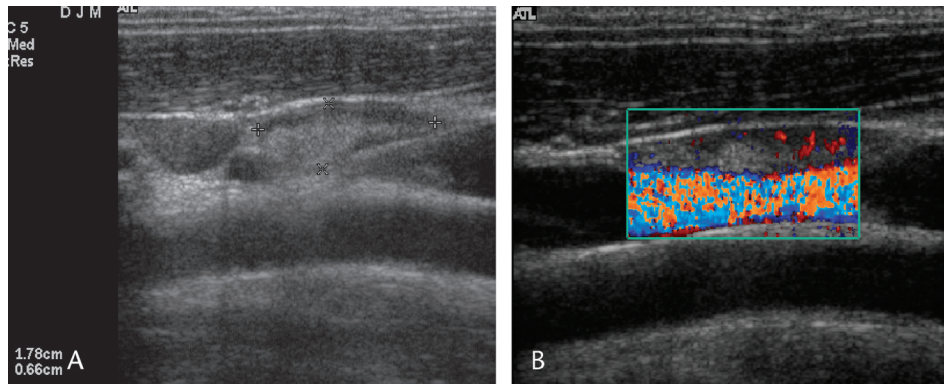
A 47-year-old man with a history of follicular carcinoma. Sagittal US of the right side of the neck, level III, shows an elongated node with a small anteroposterior diameter, thin cortex, and prominent echogenic hilum. B, Color Doppler US shows central branching vascularity. This node has a benign appearance.
